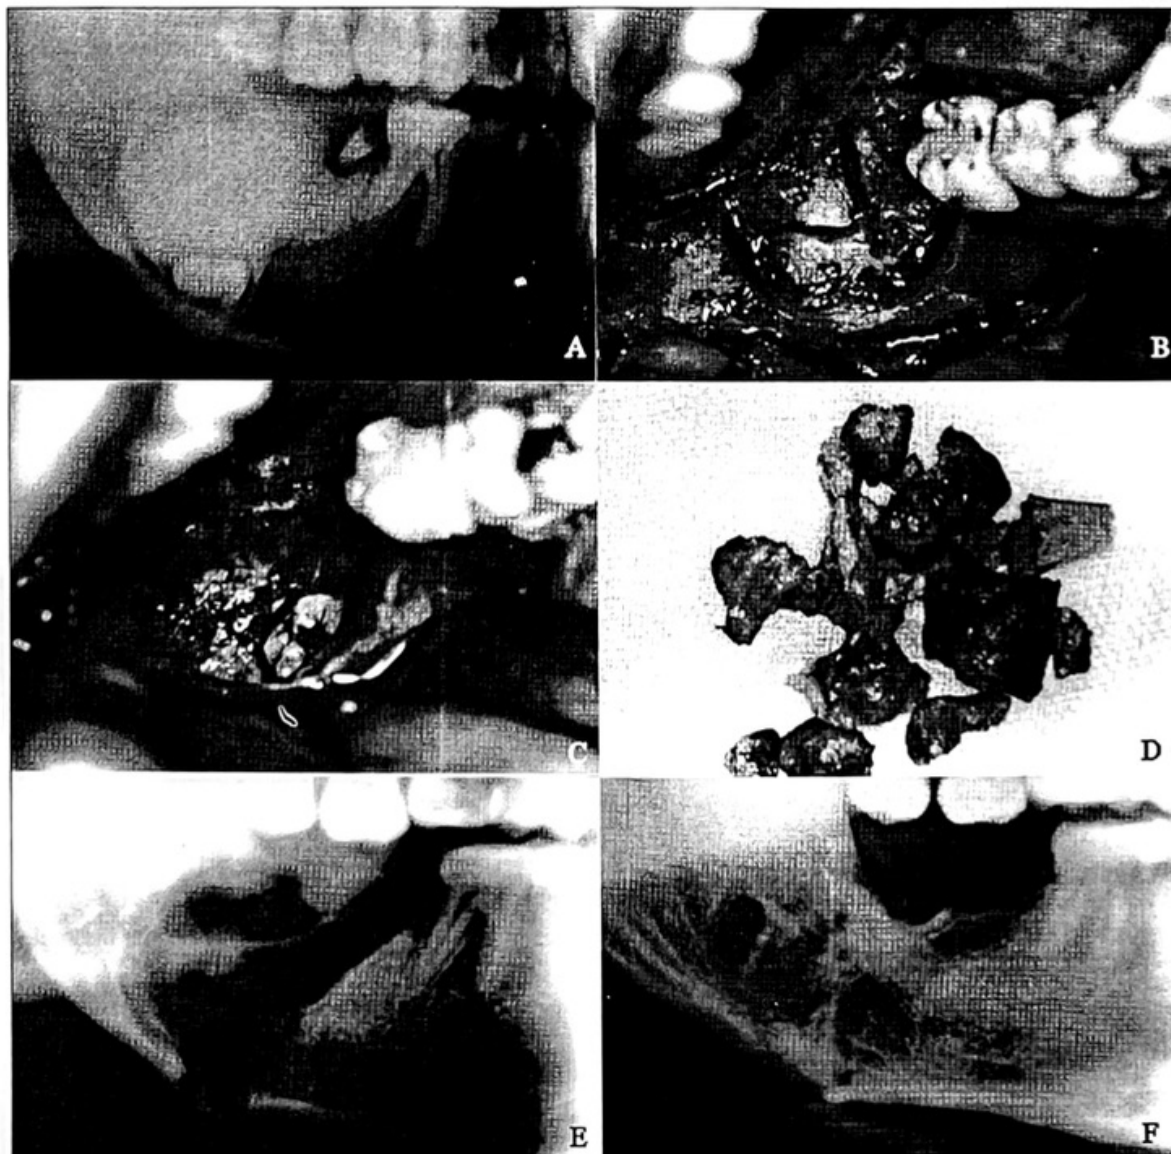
A) A panoramic radiograph showing a complex odontoma, preventing the eruption of the right mandibular third molar. B-C) Intra-operative views of the lesion. D) Tissues obtained from the excision of the odontoma. E) A panoramic radiograph showing the area of intervention immediately after surgery. F) A panoramic radiograph showing the area of intervention 12 months after surgery.
